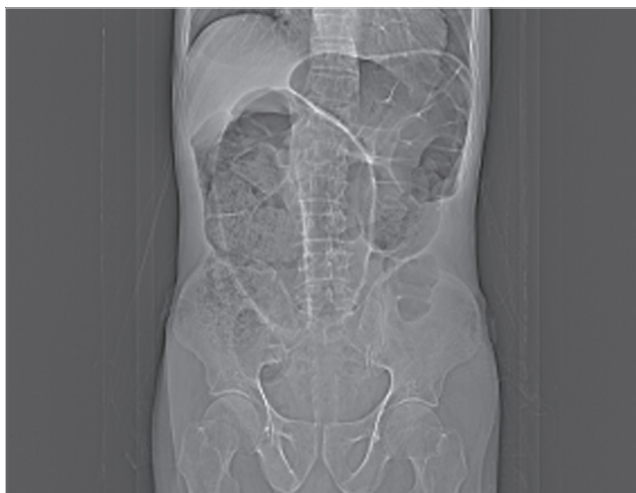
Coffee bean sign in the plain abdominal X-ray.
